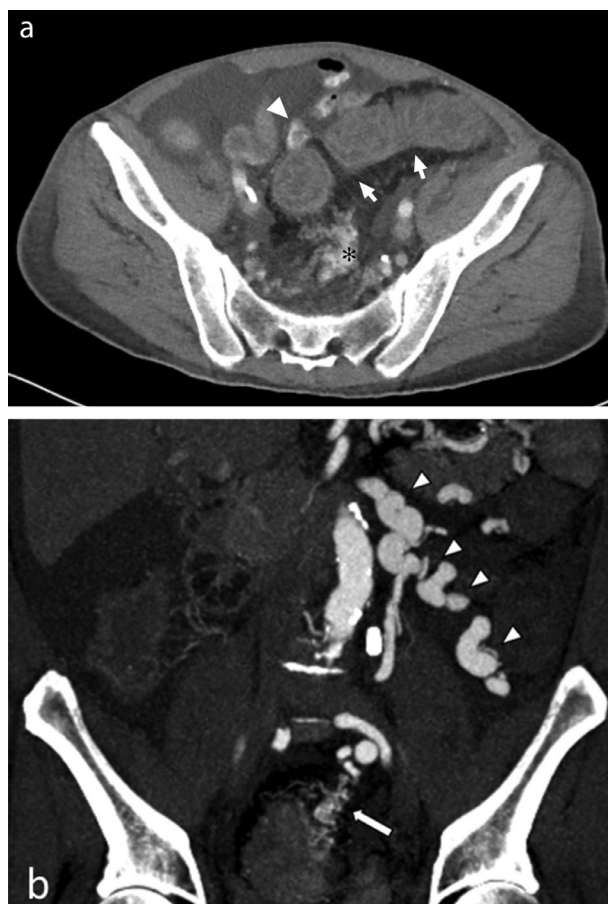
(A) Enhanced computed tomography revealed a poorly enhanced segment of the sigmoid colon (arrows). Note the well-enhanced small intestine (arrowhead) adjacent to the sigmoid colon. A cluster of abnormally engorged and tangled vessels, the nidus (asterisk), was noted in the pararectal fossa. (B) Enhanced computed tomography revealed a cluster of abnormally engorged and tangled vessels, the nidus (arrow), in the pararectal fossa. A segment of engorged left mesocolic marginal vein was noted (arrowheads).
